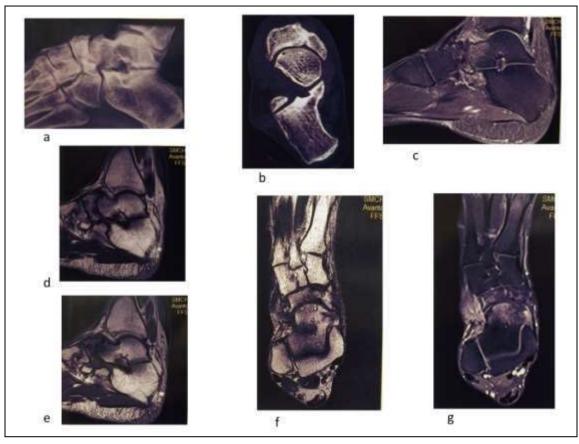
Osteonecrosis of Navicular. X ray (a), CT (b), MRI T1 Sagittal (d), T2 Sagittal (e), T2 axial (f), Post contrast Sagittal (c) and Axial (g).
